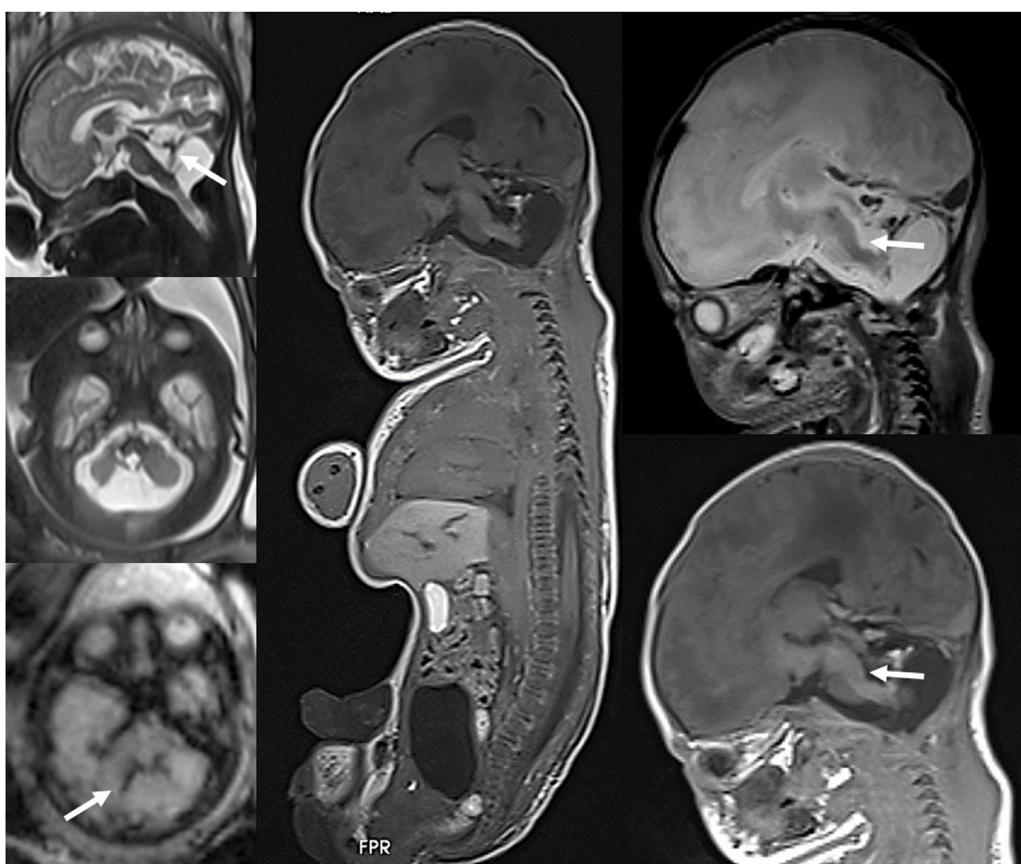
Fetus at 33 weeks of gestational age with sonographic findings indicative of cerebellar hypoplasia. (A) Fetal MRI performed at 33 weeks showing a destructive cerebellar lesion with blood remnants (arrows). (B) Post mortem fetal MRI conducted after the pregnancy was terminated showing the cerebellar hemorrhage associated with a tegmental lesion of the medulla oblongata (arrows) that was previously undetected.
